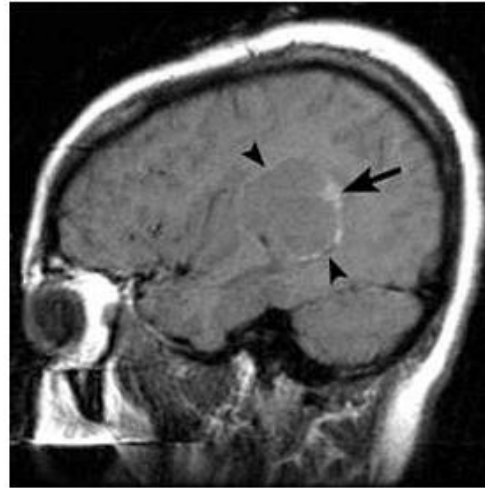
Sagittal T1 MR image shows a heterogeneous, isointense mass (arrowheads) with points of hyperintensities (arrow) indicating hemorrhage.
